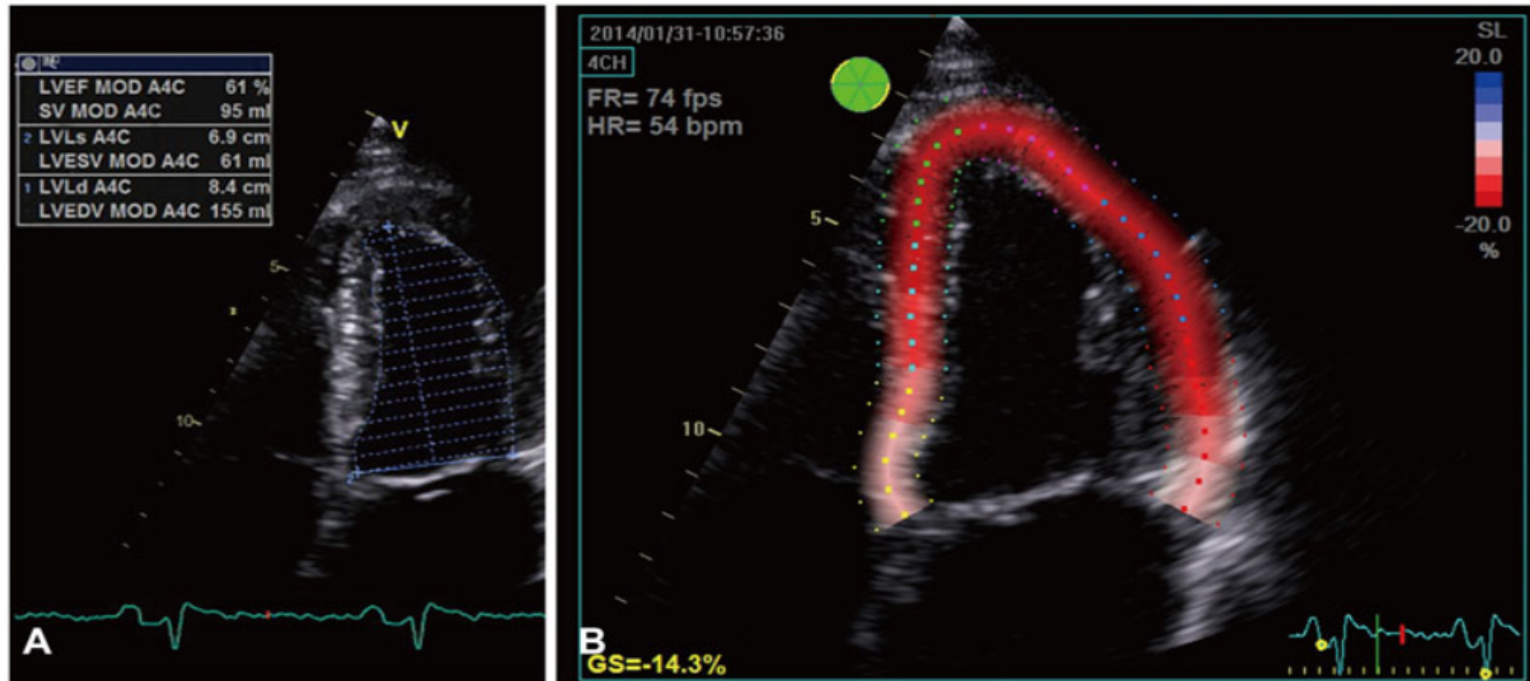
Echocardiographic images from a patient with severe asymptomatic mitral regurgitation. There is a preserved left ventricular (LV) ejection fraction calculated by Simpson's method (61%) (A), but reduced global longitudinal strain (-14.3%) (B), suggesting subclinical LV systolic dysfunction ([Supplementary Video 6](#) in the online-only Data Supplement). LVEF: left ventricular ejection fraction, SV: stroke volume, LVESV: left ventricular end systolic volume, LVEDV: left ventricular end diastolic volume.
